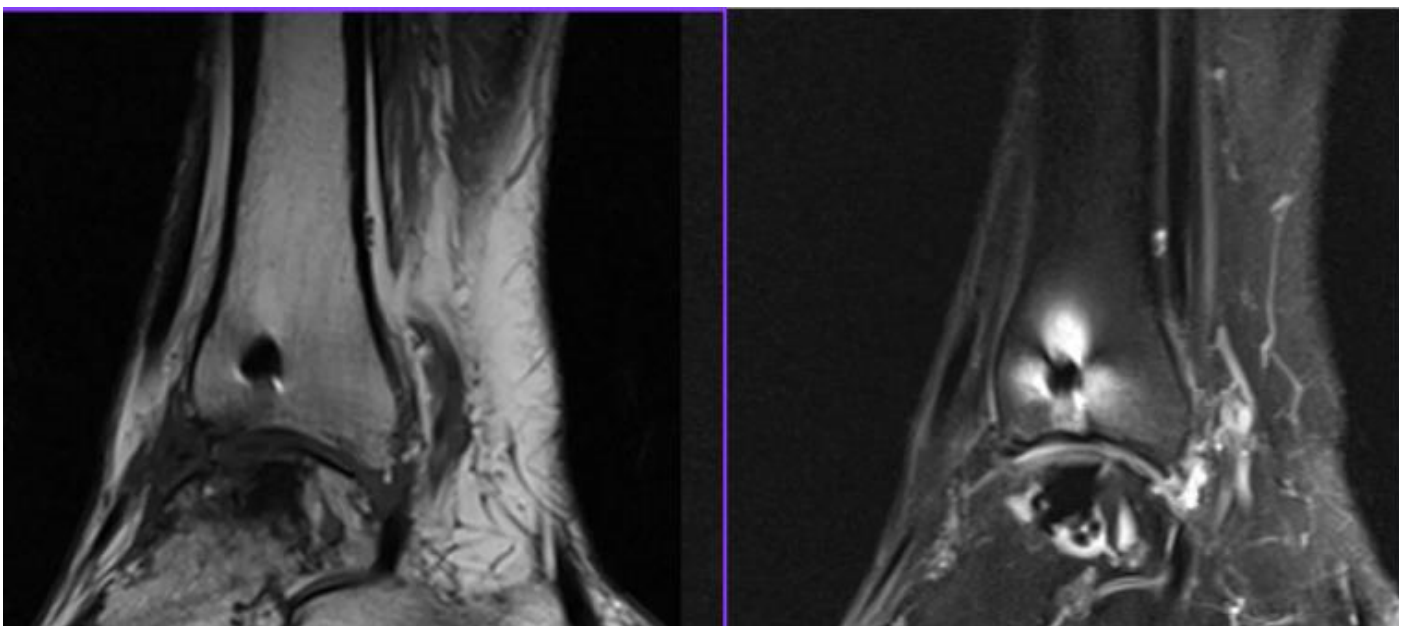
Postoperative MRI T1/PD TSE FS of the left talus after debrided cyst and instillation of calcium phosphate paste
